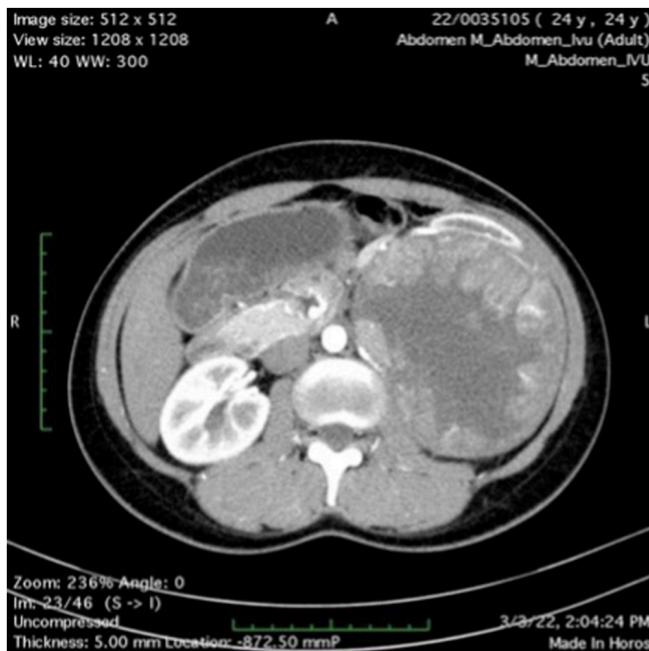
Abdomino-pelvic computed tomography scan showing left Wilms tumor (axial view).
